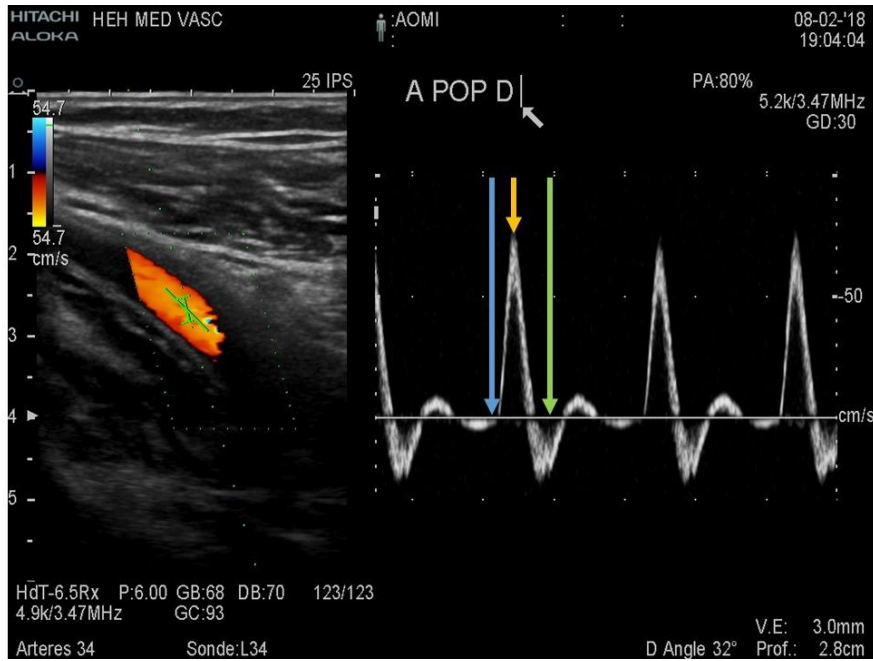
Measurement of the flow in the right popliteal artery of a healthy subject using a clinical scanner: (left) B-mode image superimposed with color Doppler, and (right) Doppler spectrum at the position of the green pointer in the image. In the spectrum, the arrows indicate the beginning of the systole (blue), the systolic peak (yellow), and the diastolic notch (green) [Courtesy of Pr. Anne Long, Hôpital Edouard Herriot, Lyon, France].
